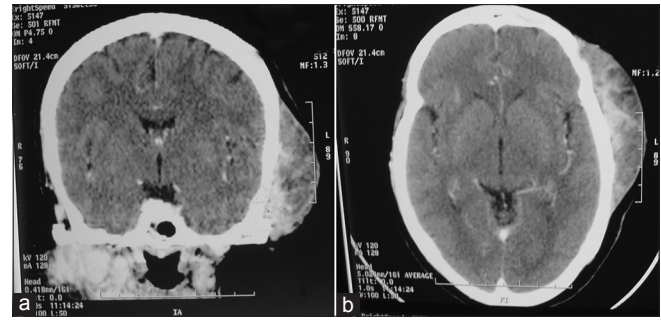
(a and b) Computed tomographic scan with axial and coronal view shows normal brain, intensely enhanced soft tissue mass in the masticator space, and infratemporal space on both sides with extension to temporoparietal convexity (extracalvarial) of the left side
